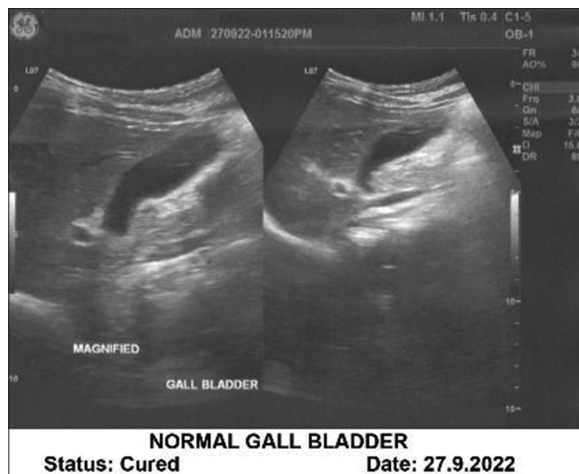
Ultrasonography findings post-treatment
